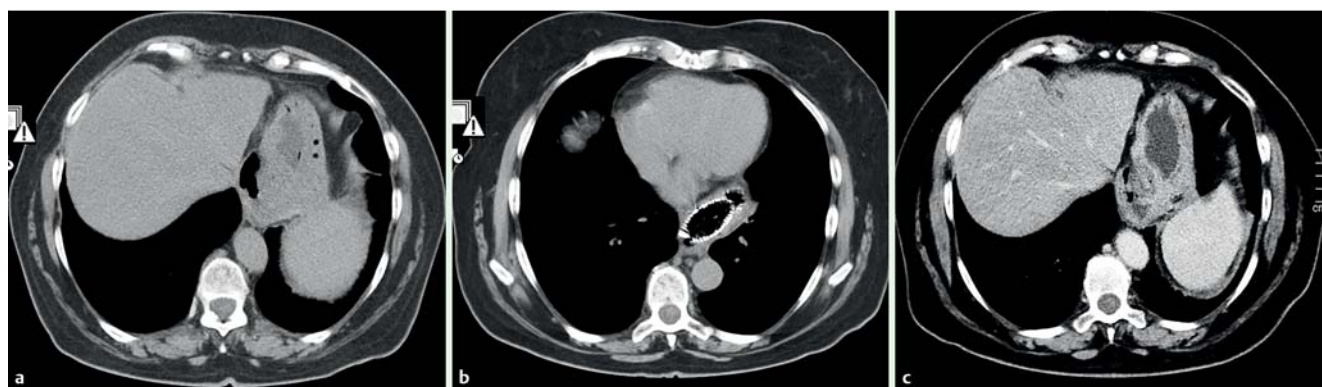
Computed tomography (CT) images showing: a an intra-abdominal air collection at the level of the fundoplication and an esophagogastric fistula; b a covered self-expanding metal stent in position to treat both the esophageal stricture and the fistula; c a reduction in the size of the intra-abdominal air collection after removal of the stent and healing of the fistula 6 weeks later.
